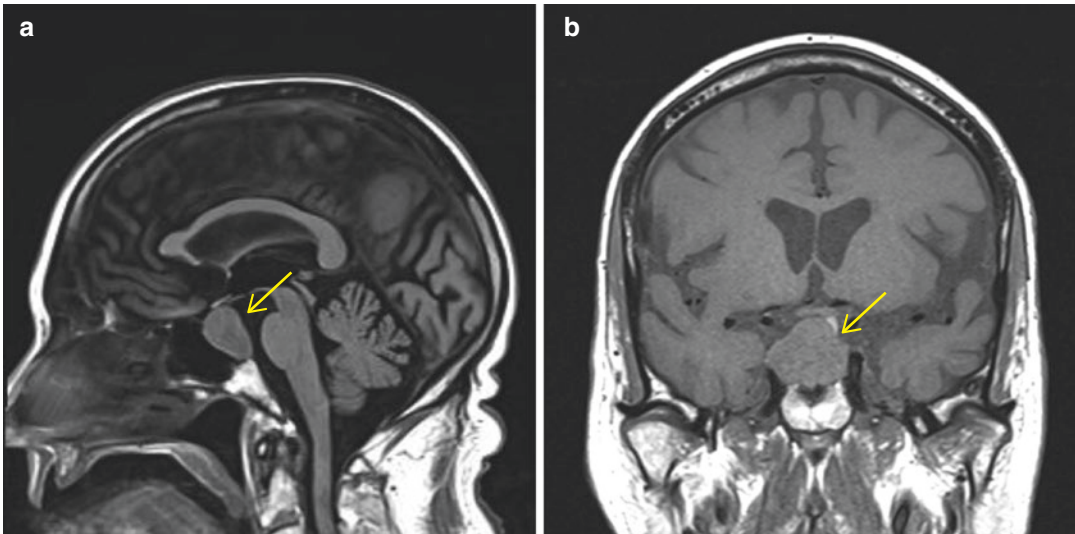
Non-functional macroadenoma. (a) FLAIR sagittal image. (b) T1 coronal image
